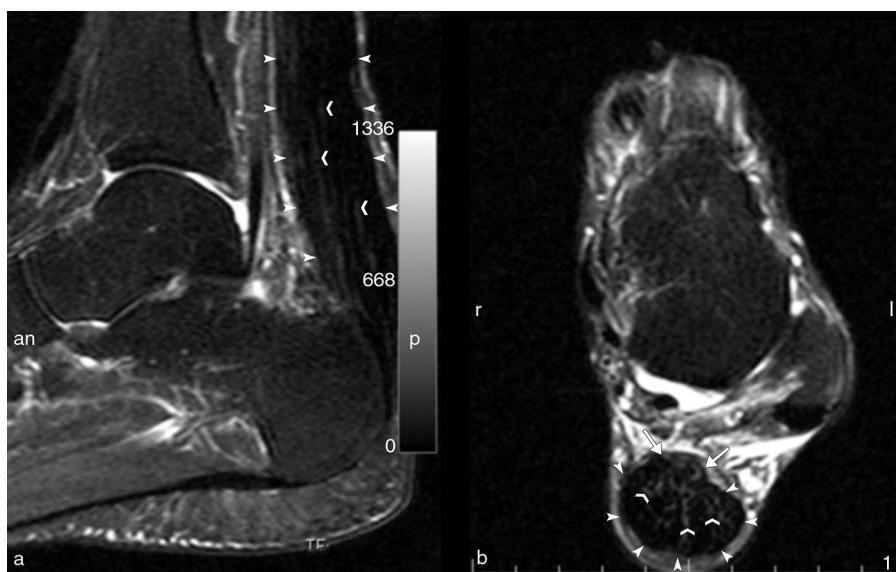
STIR magnetic resonance imaging of the Achilles tendo in a patient with a xanthoma. (a) sagittal plane (A: anterior, P: posterior) and (b) cross-sectional plane (D: right; E: left) showing a diffuse thickening and a reticulate pattern of the tendon (arrowheads). Arrowheads mark outline the Achilles tendon. Of note, the ventral margin of the tendon has a convex outline in cross-sectional plane (arrows).
